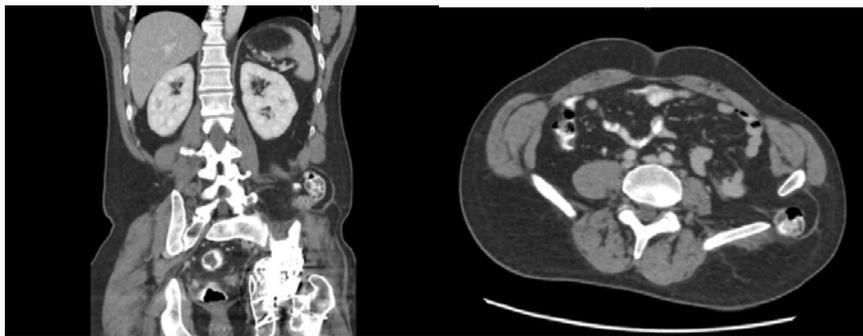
Coronal (left) and axial (right) CT view of the traumatic hernia.
